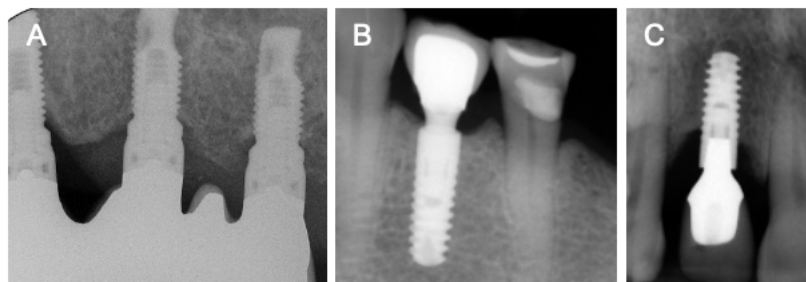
Radiographic images from Figure 3 cases (34) . (a) Peri-implant health. (b) Peri-implant mucositis. (c) Peri-implantitis
